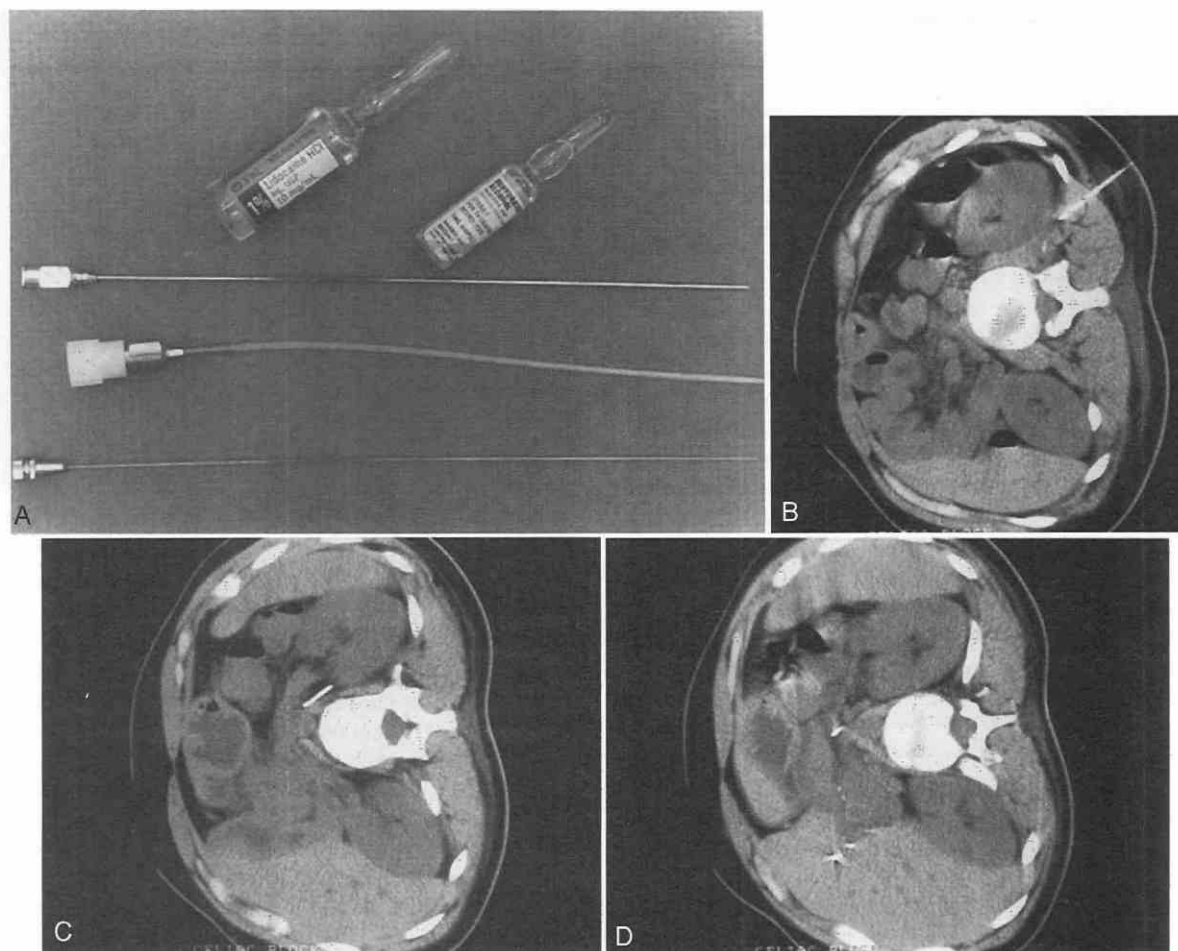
A, The equipment used for nerve blocks include a plastic sheath needle (sheath, needle, and stylet are disassembled), lidocaine anesthesia, and ethanol. B, This and the subsequent CT scan shows the appropriate positioning for a celiac nerve block. This scan shows the introduction of the needle into the retroperitoneum on the left. C, With cephalad angulation, the needle is passed behind the renal pedicle and then passed beside the aorta. D, This scan shows final placement of the needle tip beside the superior mesenteric artery behind the pancreas. One should note that even if inadvertent penetration of the vessels should occur, any adverse developments are unlikely (see text under other methods as proposed by Lieberman).
